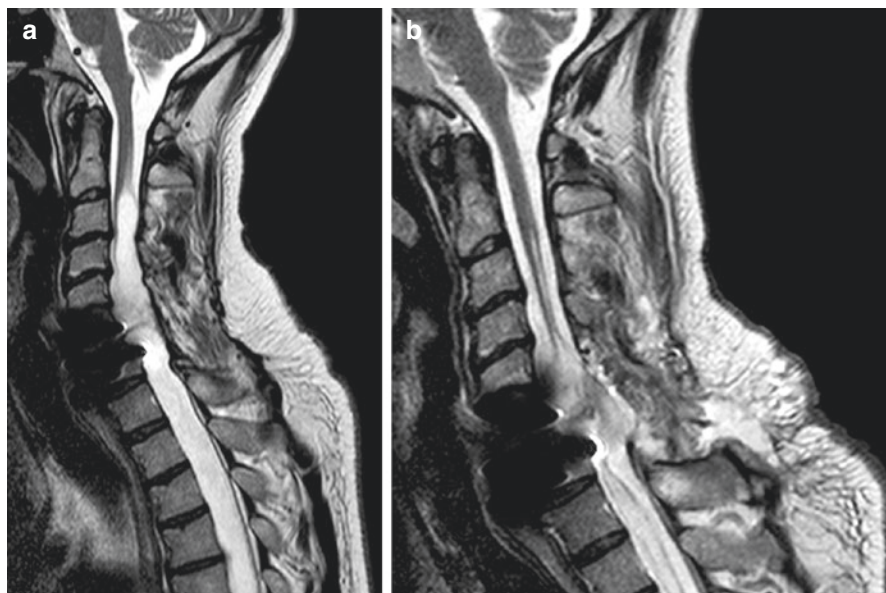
(a) This T2-weighted MRI scan shows a huge posttraumatic syrinx almost 20 years after a complete cord lesion due to a dislocated C7 fracture in a 46-year-old man with progressive motor weakness of his hands. A first surgical attempt with arachnolysis and duraplasty at C6/7 stabilized the neurological status for 30 months. (b) The postoperative scan after corpectomy at C7 demonstrates the complete collapse of the syrinx
